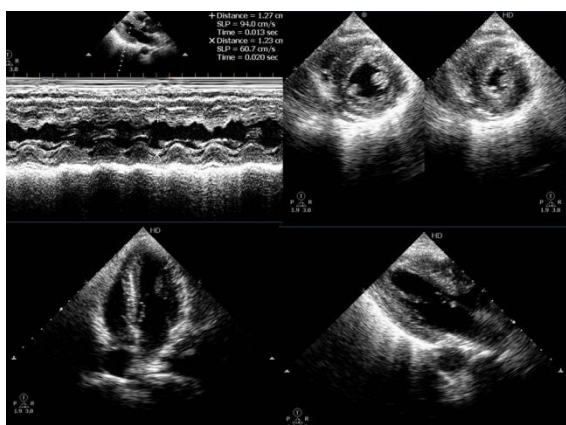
2D-Echocardiograph showing normal chambers with no regional wall motion abnormalities.
